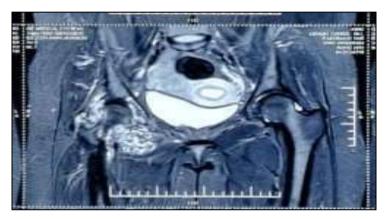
Magnetic resonance imaging skew synovial osteochondromatosis inside hip joint
